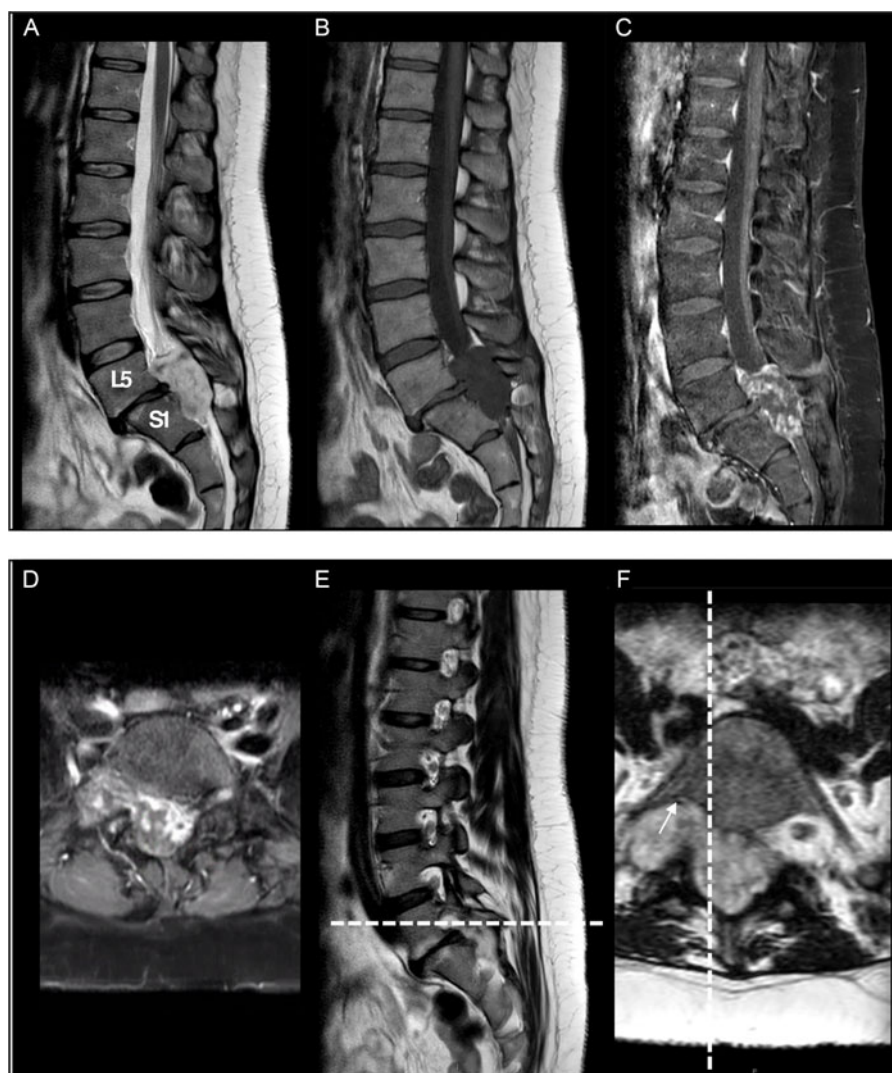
Preoperative parasagittal and axial MR images showing a well-circumscribed intradural extramedullary L5-S1 mass extending to the right-sided L5-S1 neural exit foramen without bone destruction. Hyperintensity on T2-weighted image (A), although of lower T2 signal than CSF. Isointensity on T1-weighted image (B). Peripheral heterogeneous rim enhancement following gadolinium administration, sagittal view (C) and axial view (D). Nerve roots of the cauda equina are compressed by the mass and indistinguishable from the exiting right L5 nerve root (indicated by an arrow), sagittal view (E) and axial view (F).
